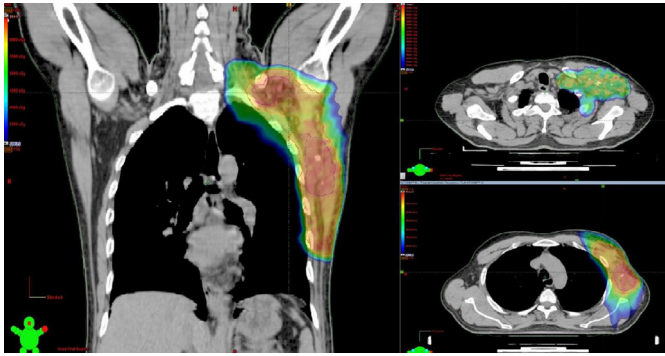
Planning CT scan showing dose colour wash of IGRT plan with Simultaneous Boost: (Red) 66Gy for gross disease and (Yellow) 60Gy tumour bed.
